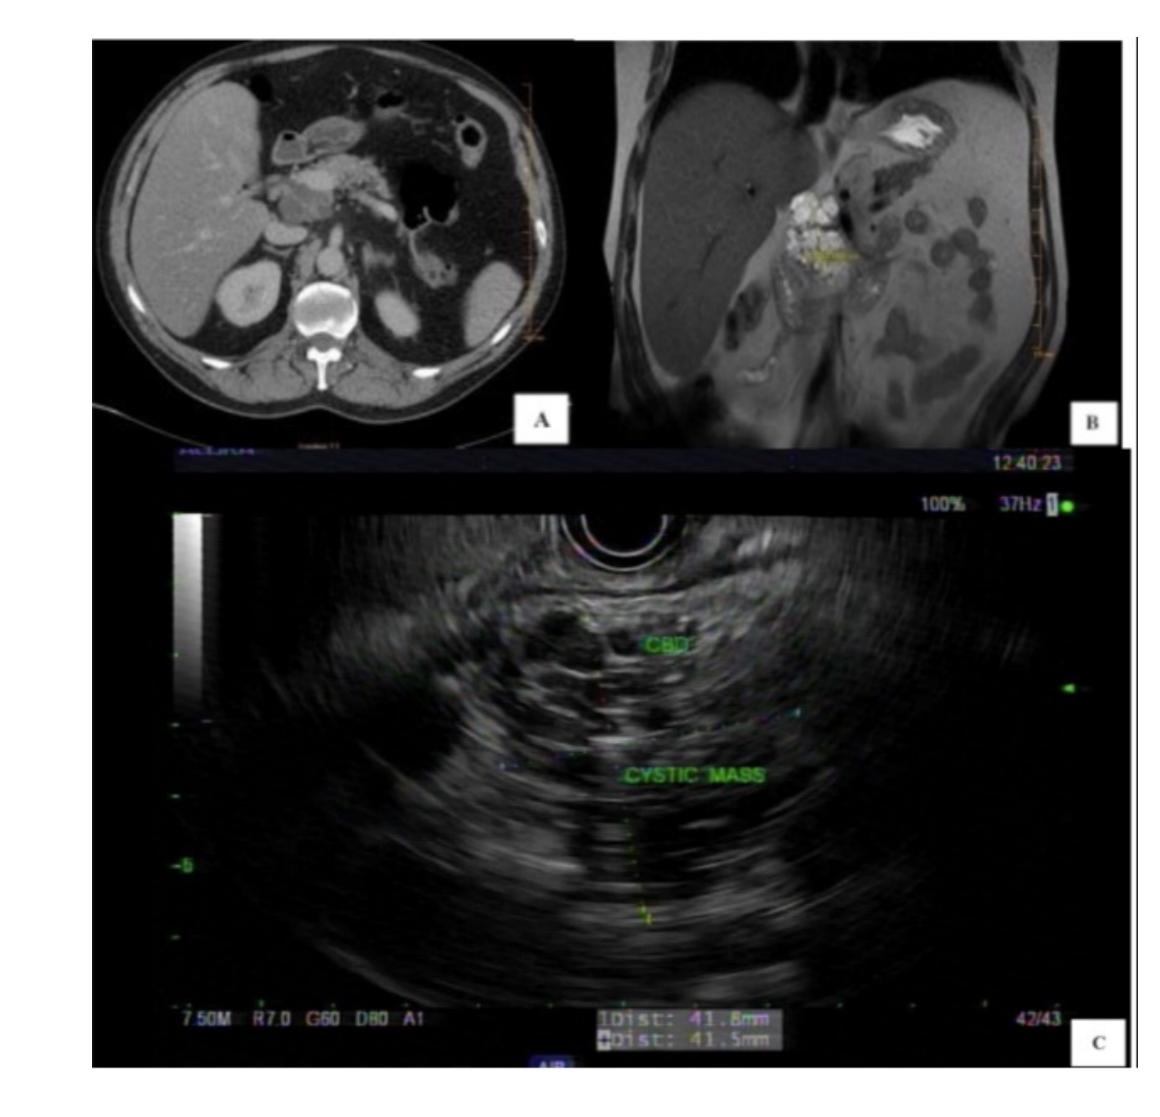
Radiographic findings in the patient diagnosed with acinar cell cystadenoma.
